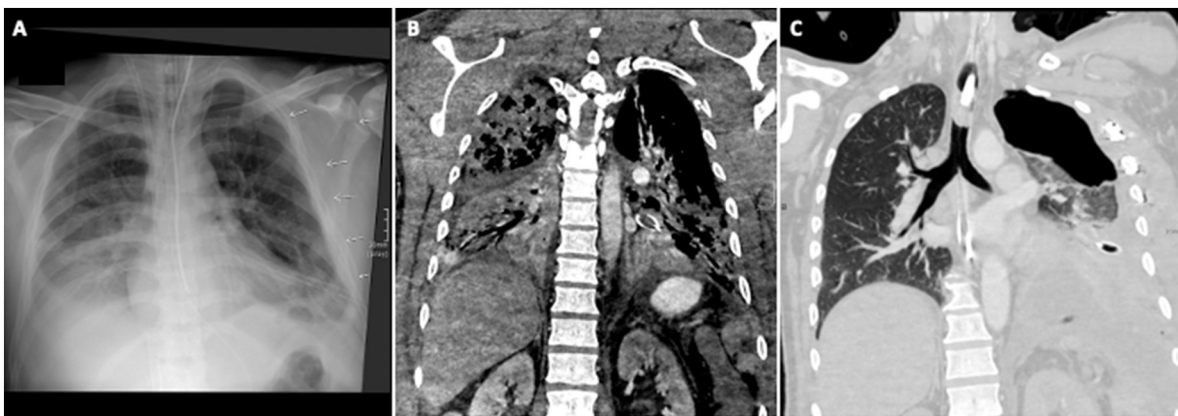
Sequential imaging of thoracic trauma: radiographic and CT findings.
